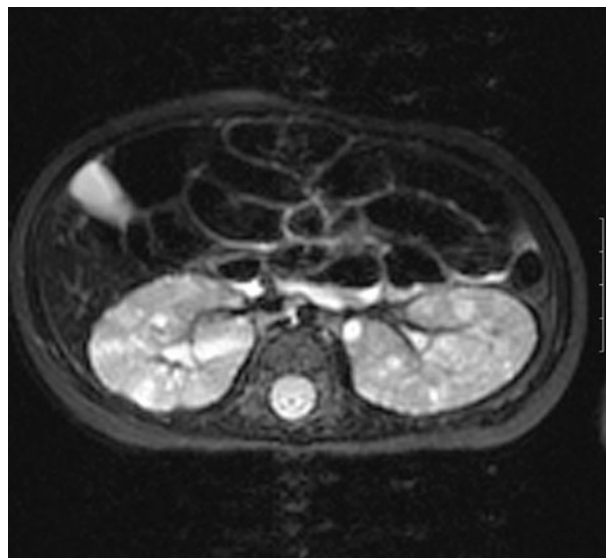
Magnetic resonance image in a five-month-old with tuberous sclerosis. This axial STIR sequence shows multiple cysts in both kidneys. These are easily demonstrated by ultrasound, but magnetic resonance imaging is also performed to exclude liver or pancreatic involvement.
